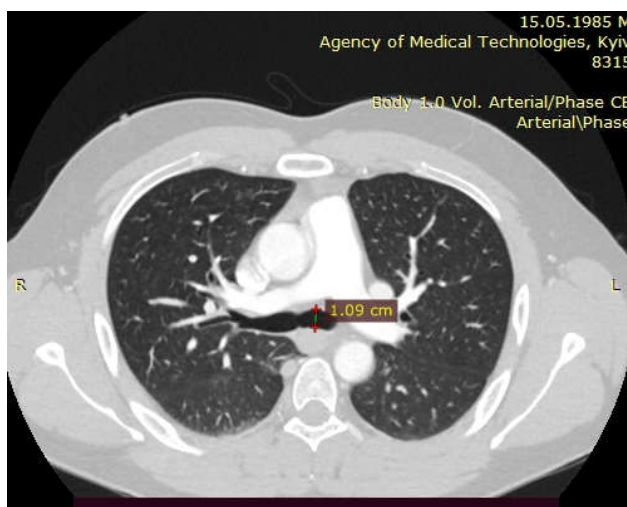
The diameter of the left main bronchus on the CT image in the axial section.
